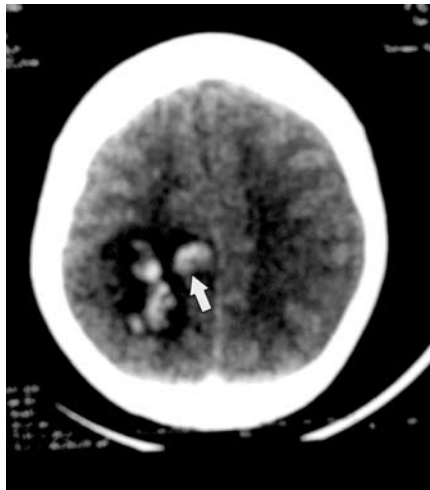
Non-contrast axial CT scan showing right parieto-occipital venous hemorrhagic infarction secondary to right transverse sinus thrombosis.
